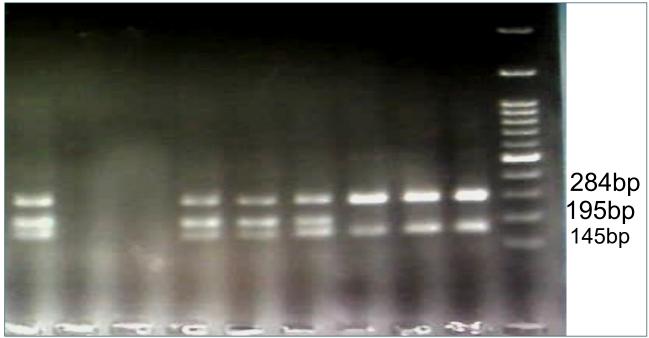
A representative 1% agarose gel electrophoresis for identification of the rs11776042 from piR-015551 gene. A:lane1:positive control,lane2&3:negative control,lane 4&5&6:heterozygote patients(CT genotype),lane7,8,9:homozygote patients(CC genotype),lane10:DNA Ladder100bp
